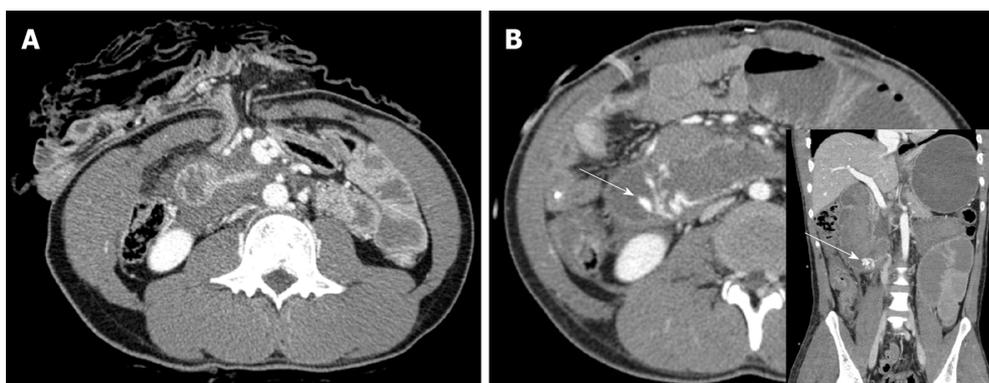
Abdominal computed tomography. A: Preoperative abdominal computed tomography (CT) shows paraduodenal fluid collection and transverse colon and small bowel herniation from the abdominal stab wound; B: Postoperative abdominopelvic CT shows extravasation of the contrast medium in the third portion of the duodenum (arrow).
